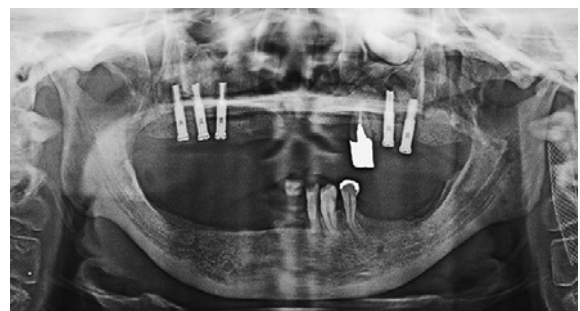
Panoramic radiograph after the upper jaw implant fixture placement
